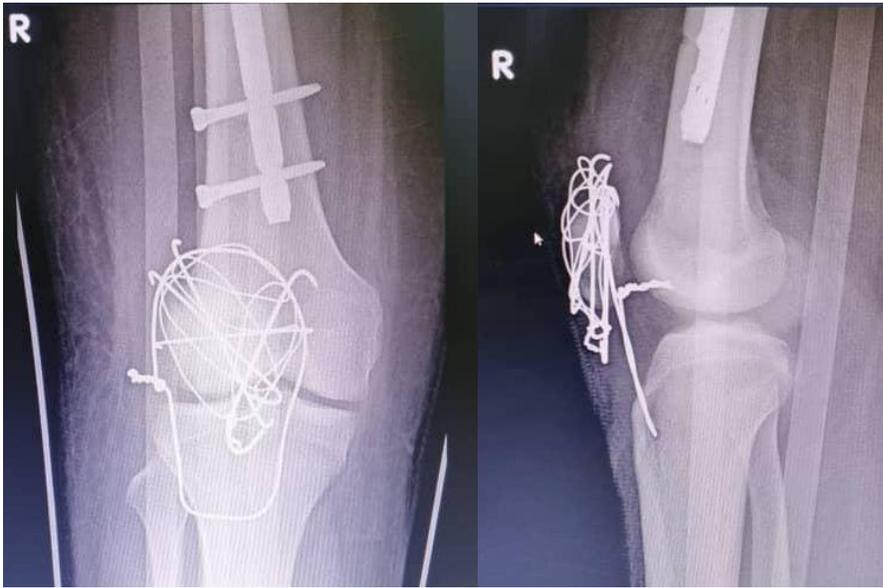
Post operative check radiograph – patella fixation with a tension relieving wire.
